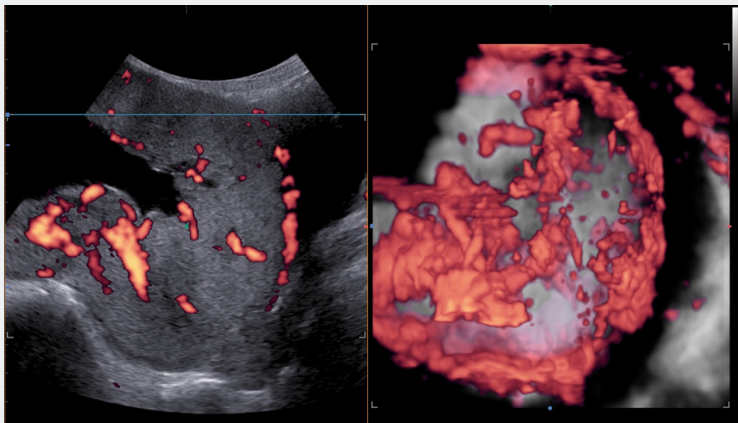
Three dimensional power Doppler in case of placenta percreta. This image shows the irregular intraplacental vascularization with tortuous confluent vessels crossing placental width.
